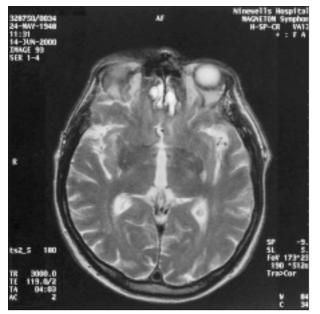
Transaxial views of MRI brain, T2 weighted sequences, showing hyperintense signal in the frontal lobes with a surrounding hypointense ring suggestive of haemosiderin.
